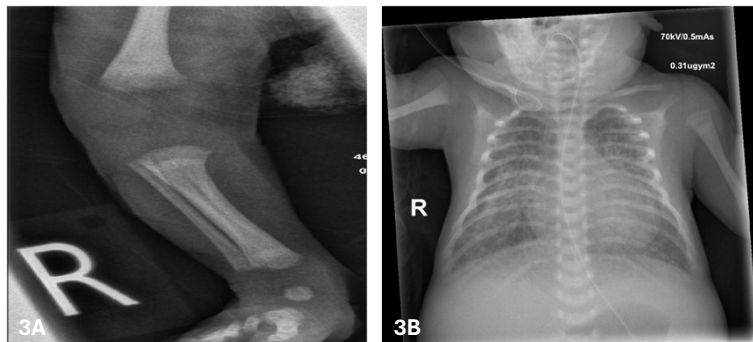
Long bone lucencies along metaphysis of distal femur, proximal tibia and fibula consistent with congenital syphilis. 3B: Chest Xray showing bilateral nodular density, confluent in right middle lung, consistent with pneumonitis of congenital syphilis.
